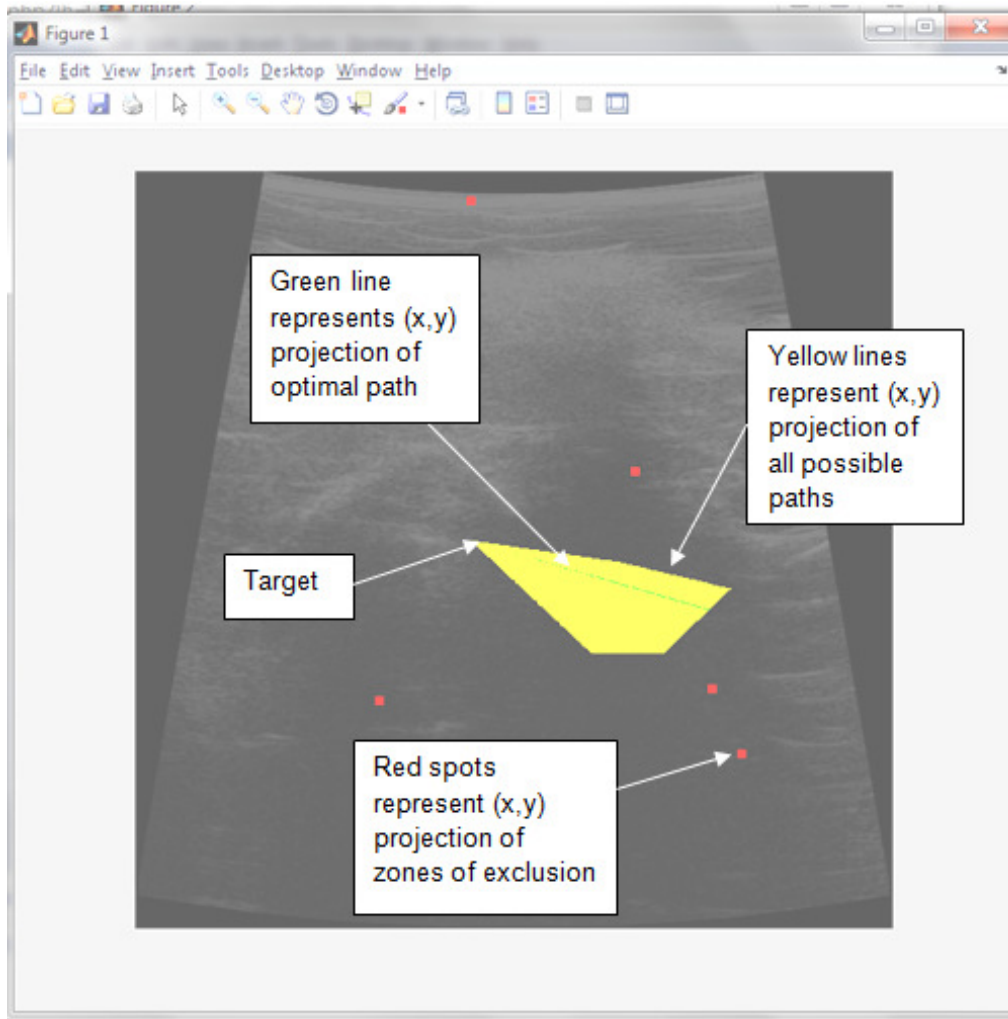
Projection onto first Ultrasound Slice for Selective Minimum Path
